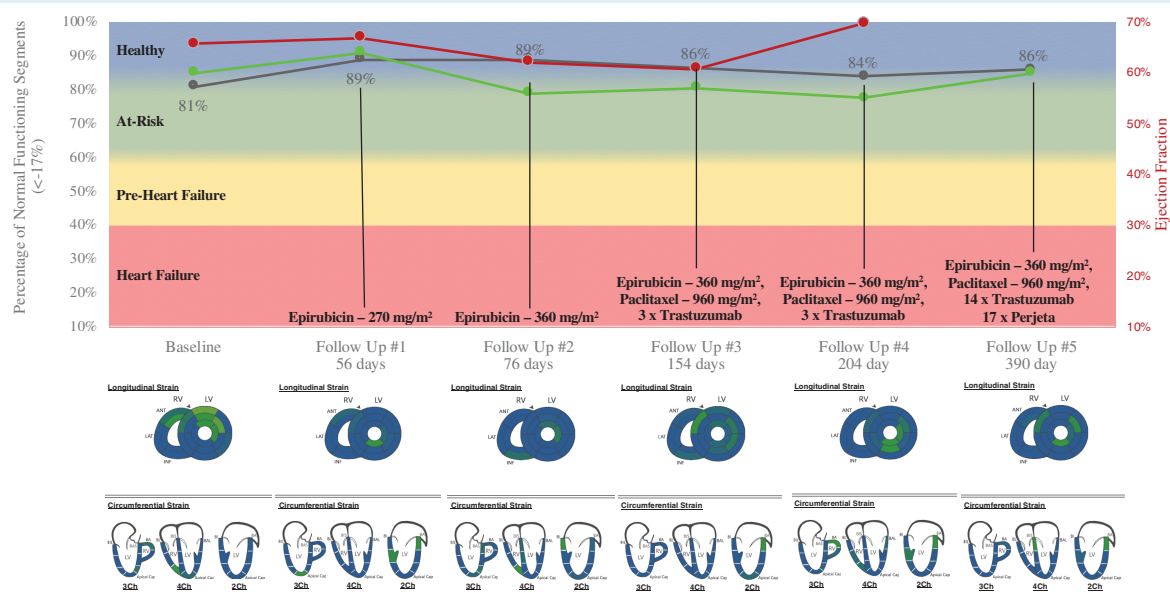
The case of a 58-year-old female suffering from HER2+ right breast cancer with a high baseline risk of cardiotoxicity. Cardiac magnetic resonance exams including Fast-SENC MyoStrain testing were performed at baseline and five follow-up intervals through 390 days after initiation of chemotherapy with no signs of cardiac damage. The graph shows % normal MyoStrain ($\leq -17\%$) in black with cardiac magnetic resonance left ventricular ejection fraction in green and echocardiography left ventricular ejection fraction in red. MyoStrain segmental reports are shown below the graph of % normal MyoStrain (blue colour codes normal deformation, green codes strain in the range between -17% and -10% , yellow codes strain less than -10%). HF, heart failure.
